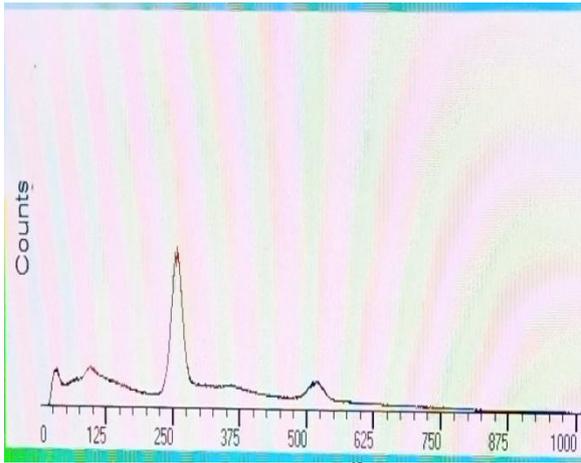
^{68}Ga PSMA-11
